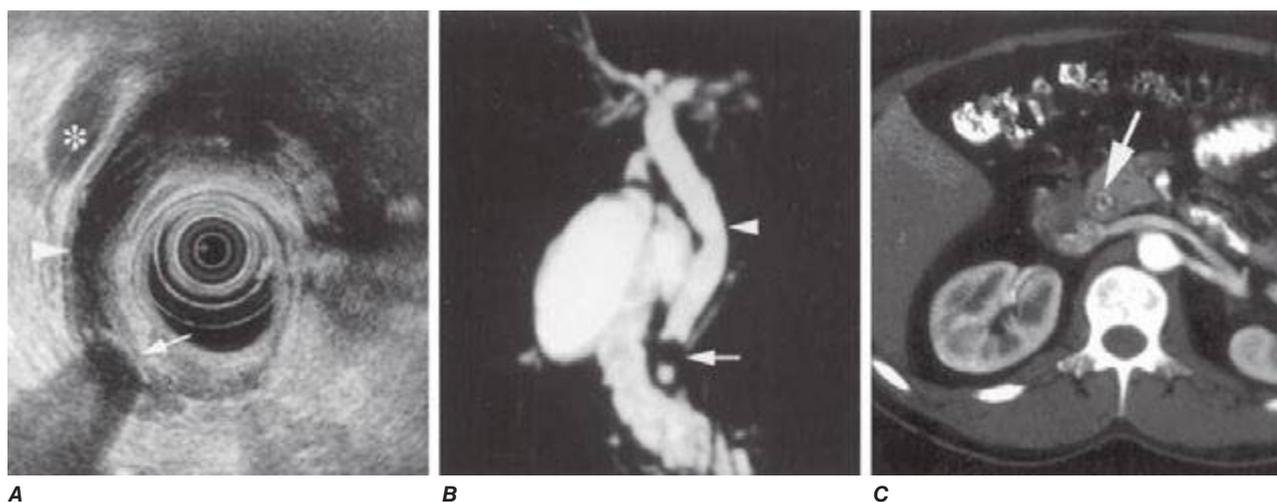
Methods of bile duct imaging. Arrows mark bile duct stones. Arrowheads indicate the common bile duct, and the asterisk marks the portal vein. A. Endoscopic ultrasound (EUS). B. Magnetic resonance cholangiopancreatography (MRCP). C. Helical computed tomography (CT).
